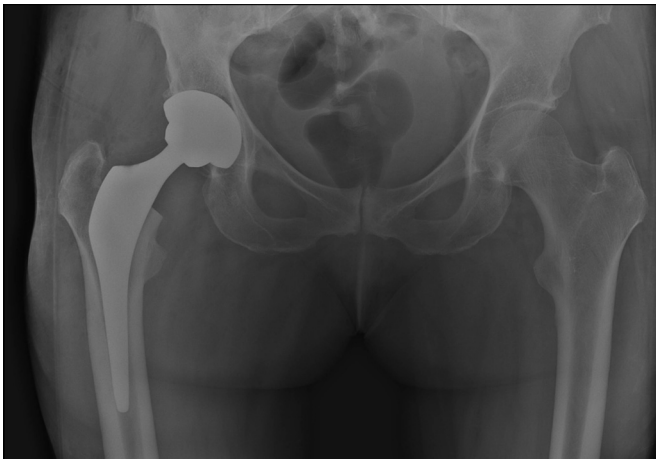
X-ray on the pelvis after THA.
